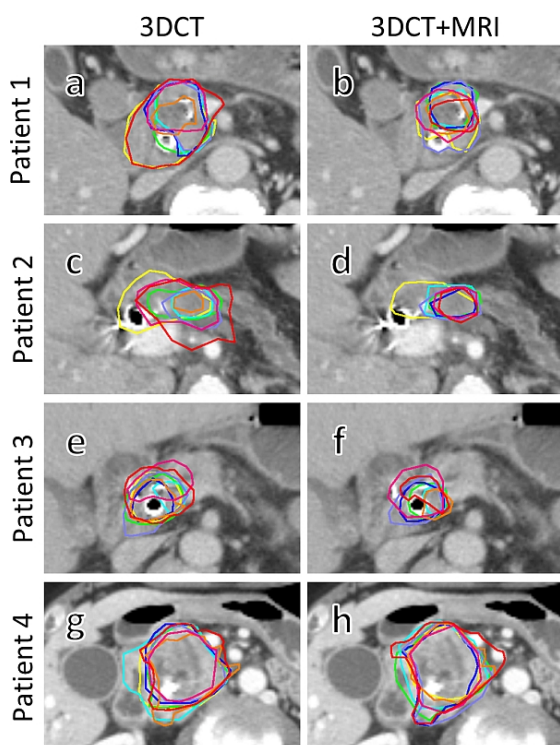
GTV delineations by the eight observers (each a different color) for 3DCT+MRI and 3DCT.
